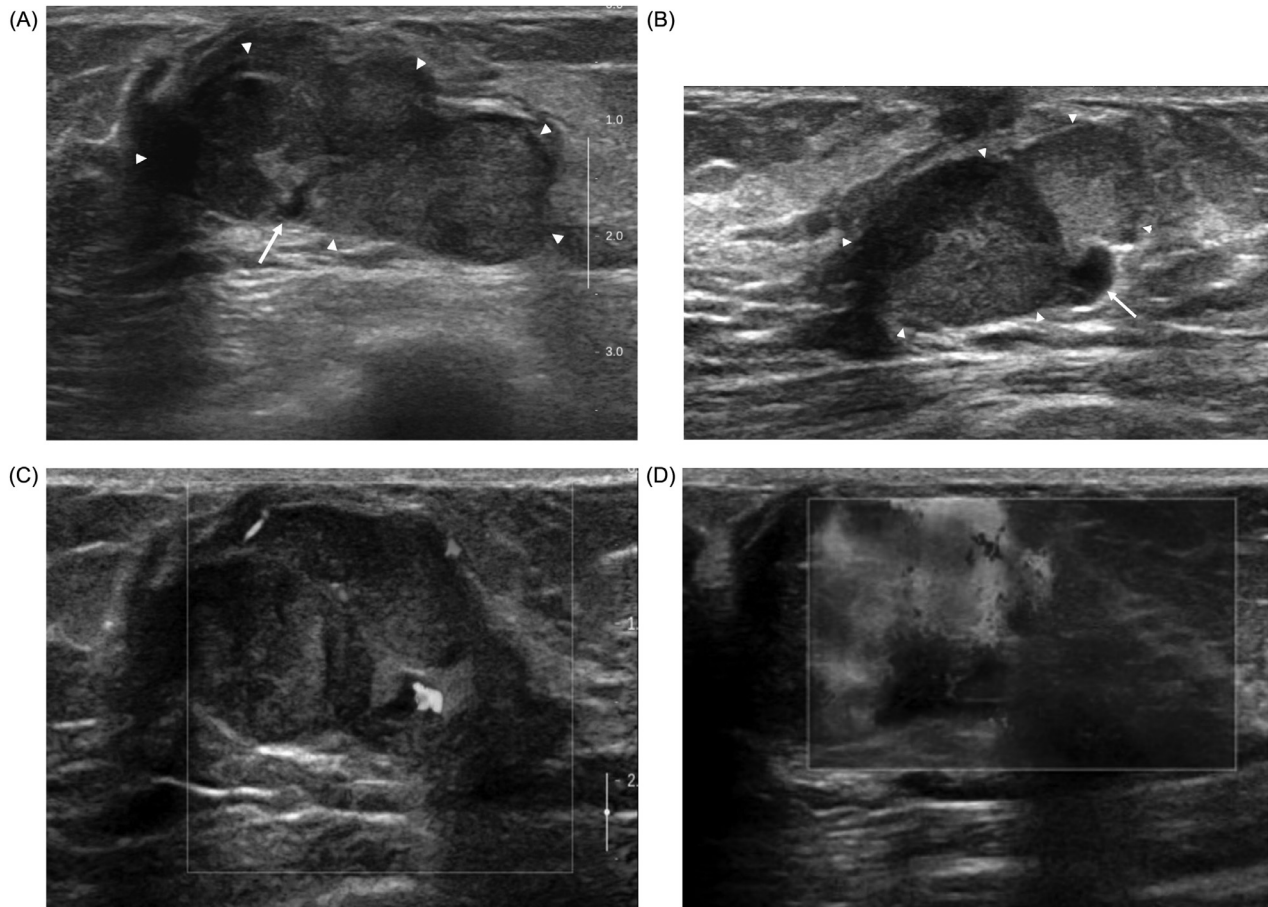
Transverse and longitudinal views of gray-scale ultrasound show a circumscribed, solid mass with heterogeneous internal echotextures (arrowheads) and focal anechoic area (arrow) in the peripheral portion of the mass (A, B), and color Doppler sonography demonstrates increased intralesional vascularity (C). On shear wave elastography, the mass showed intermediate elasticity (D)
